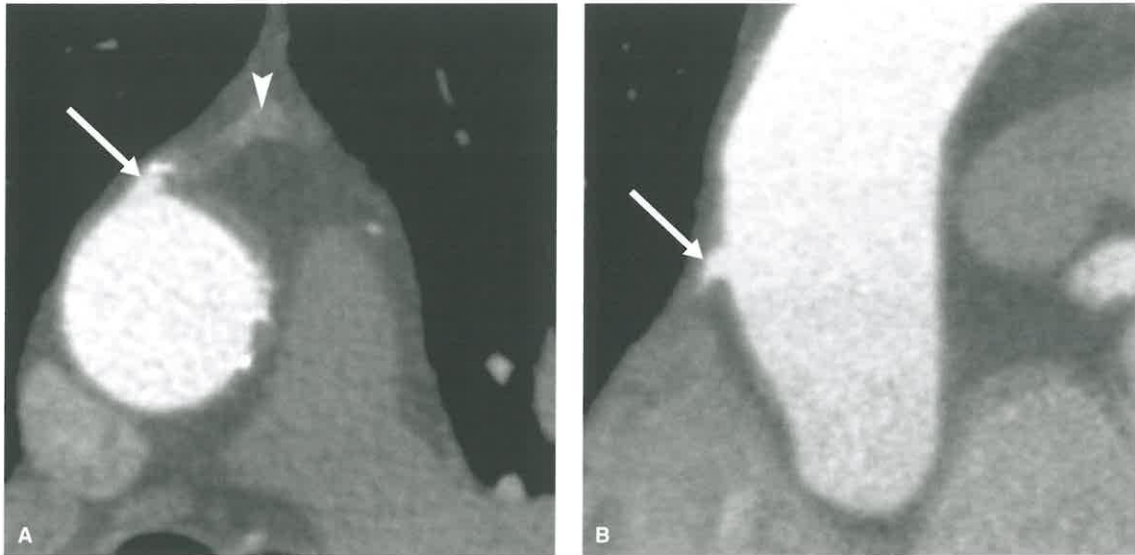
Saphenous Vein Graft (SVG) Occlusions on Coronary CTA in a 64-Year-Old Woman With a History of CABG. A: Axial oblique image through the ascending aorta shows a small outpouching from the aorta (*white arrow*) with a subtle thrombosed saphenous vein to diagonal bypass graft (*white arrowhead*). B: The patient's saphenous vein to posterior descending artery bypass graft (*white arrow*) was also thrombosed. The appearance of these small outpouchings from the aorta has been referred to as the "nubbin sign."
